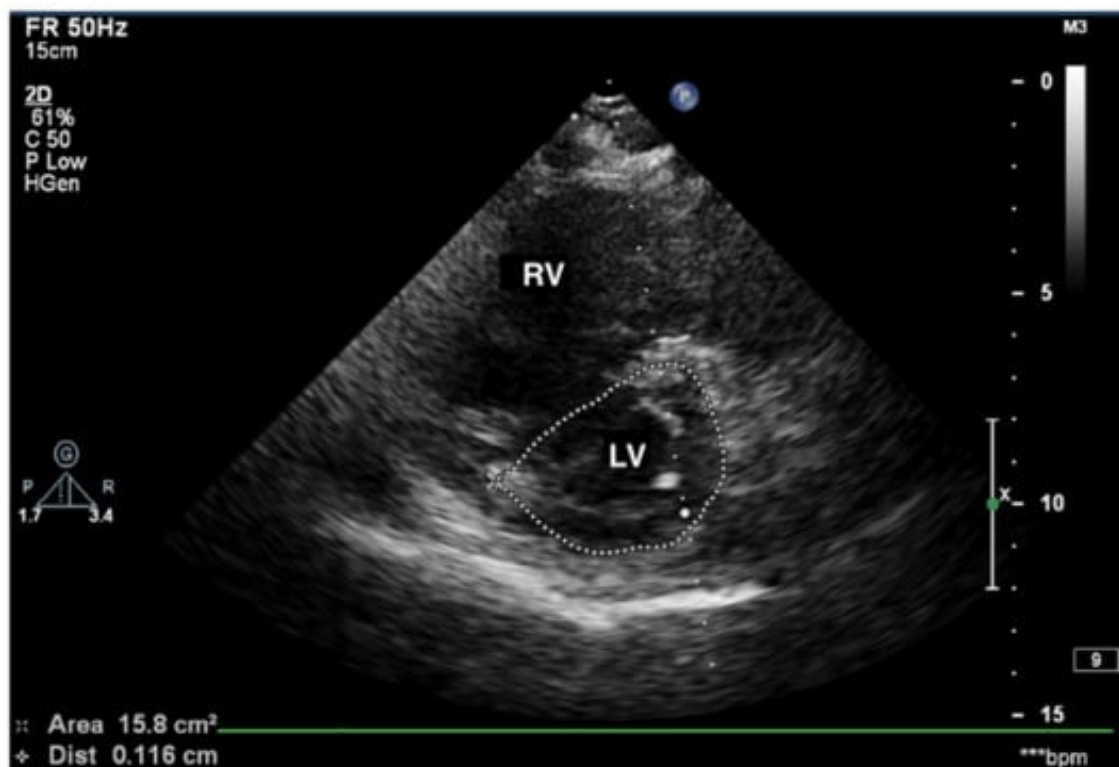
Short axis view of echocardiogram demonstrating dilated Right ventricle seen in pulmonary hypertension
